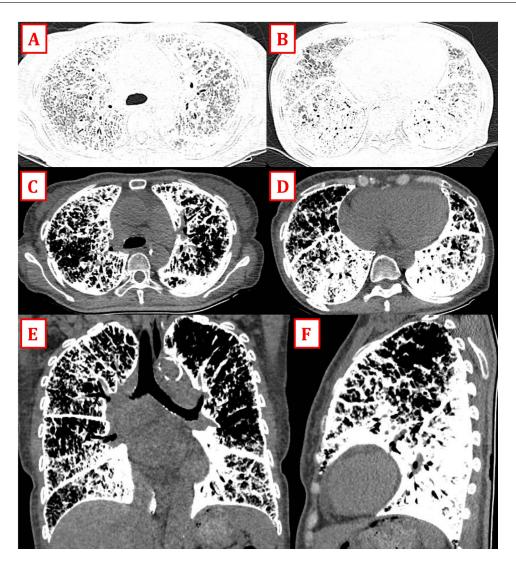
Chest computed tomography. (A and B) show extensive calcified lesions, interlobular septal thickening, and ground-glass opacities create a "crazy paving" pattern. (C and D) highlight calcifications predominantly in the lower lobes and peripheral regions, with thickened and calcified interlobar fissures. (E and F) provide detailed views of the lesions across different lung planes.
